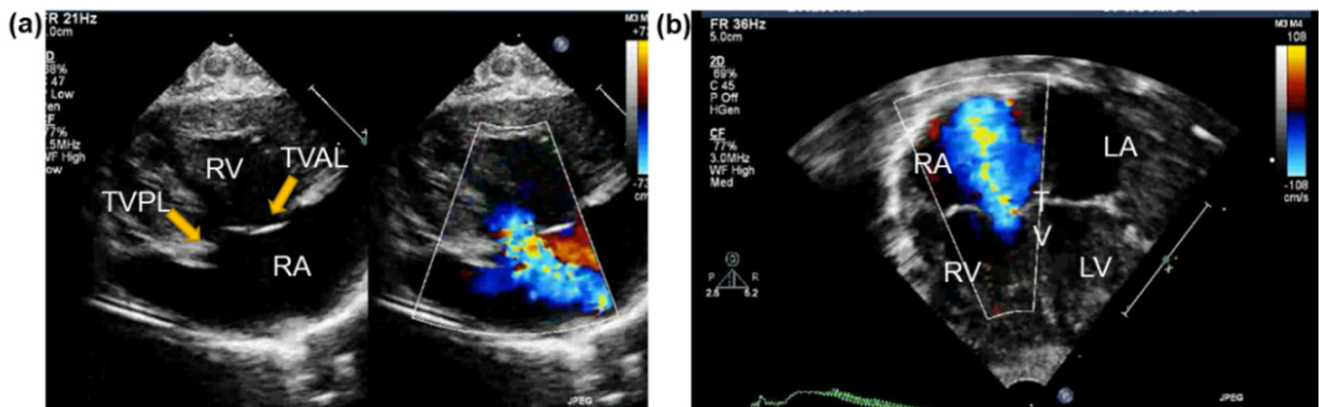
Visualization of severe TR using two different 2DTTE views and color flow Doppler: (a) a parasternal long-axis inflow view, and (b) an apical four-chamber view of a newborn with a severe pulmonary hypertension (PH) due to diaphragmatic hernia.
